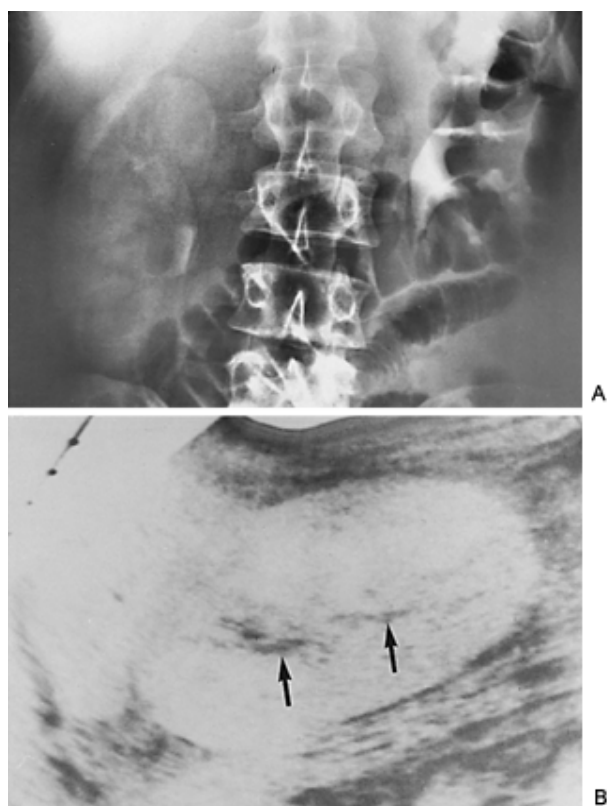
Acute pyelonephritis. A: Excretory urogram. Ten-minute film demonstrates enlarged right kidney with minimum function. Findings are consistent with edema. B: Ultrasound of the right kidney demonstrates renal enlargement, hypoechoic parenchyma, and compressed central collecting complex (*arrows*).
